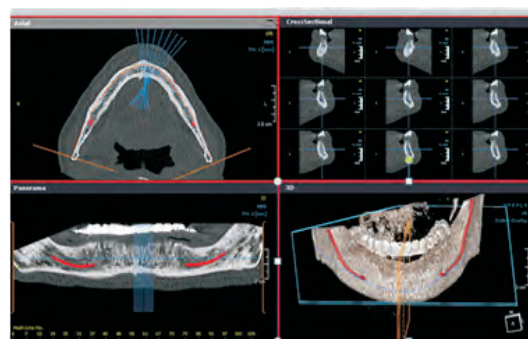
Radiographic Guide
